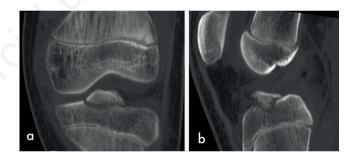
Pre-operative computed tomography scan of the knee showing the fracture of the intercondylar eminence (a: reconstruction of the coronal view; b: sagittal view).
